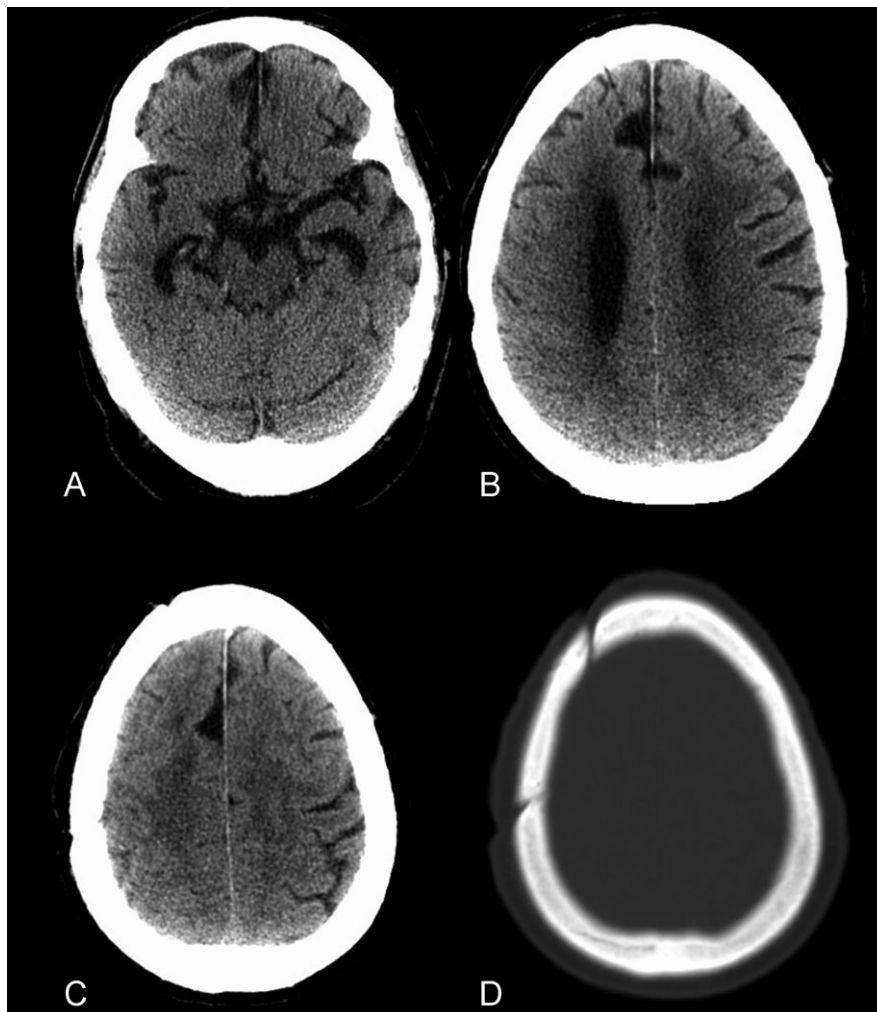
Posttraumatic hydrocephalus. (A,B) The axial computed tomography images show dilatation of the ventricles, including the temporal horns, bilaterally. (C) There is partial effacement of the convexity sulci, which indicates that the enlargement of the ventricles is partially due to hydrocephalus. (D) An image displayed in the bone window shows evidence of a right frontal craniotomy from decompression of a prior intracranial hemorrhage.
